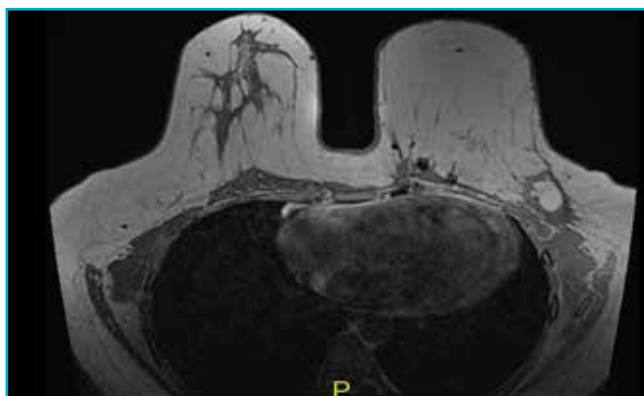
Magnetic resonance imaging (MRI) images showing multiple coalescent lesions with central fat signal intensity and a thick, irregular peripheral rim enhancement seen along the posterolateral margin of the flap in the reconstructed left breast, the largest measuring approximately 30 mm x 27 mm. Mild surrounding parenchymal oedema pattern, skin thickening, and architectural distortion are also noted.
